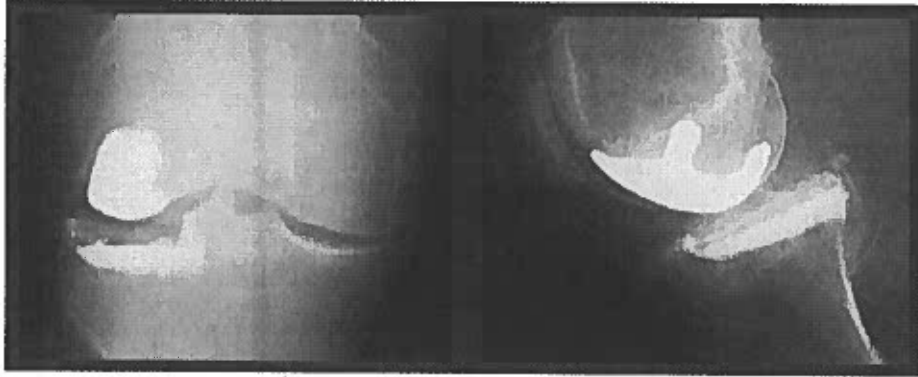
Post-operative x-rays following the Redish technique of cementation.
